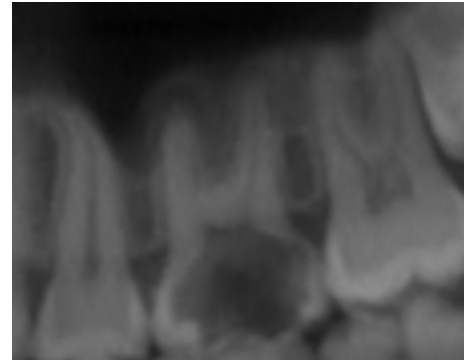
Initial Radiography
